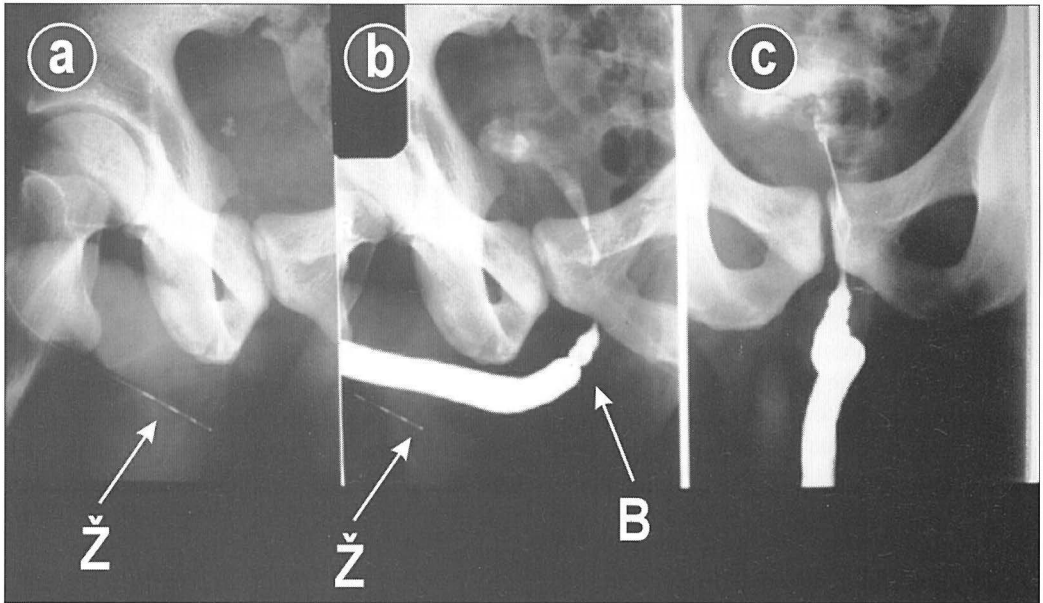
Radiographic urethrography (RUG); a,b) Correct oblique position, c) AP position with superposition of bulbar urethra. B-bulbar stricture, ž-wire measure.
